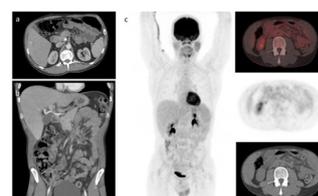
Axial CT angiography (a) with occlusion of the superior mesenteric artery (asterisk). Coronal CT angiography (b) revealed an increase in the size of mesenteric and retroperitoneal adenopathies and striking retractile mesenteritis. ^{18}F -FDG PET/CT after treatment (c) demonstrated absence of active infectious process with hypometabolic residual abdominal adenopathies and normalization of bone marrow, spleen and liver, as well as fibrosis mesenteric transformation without FDG uptake.
